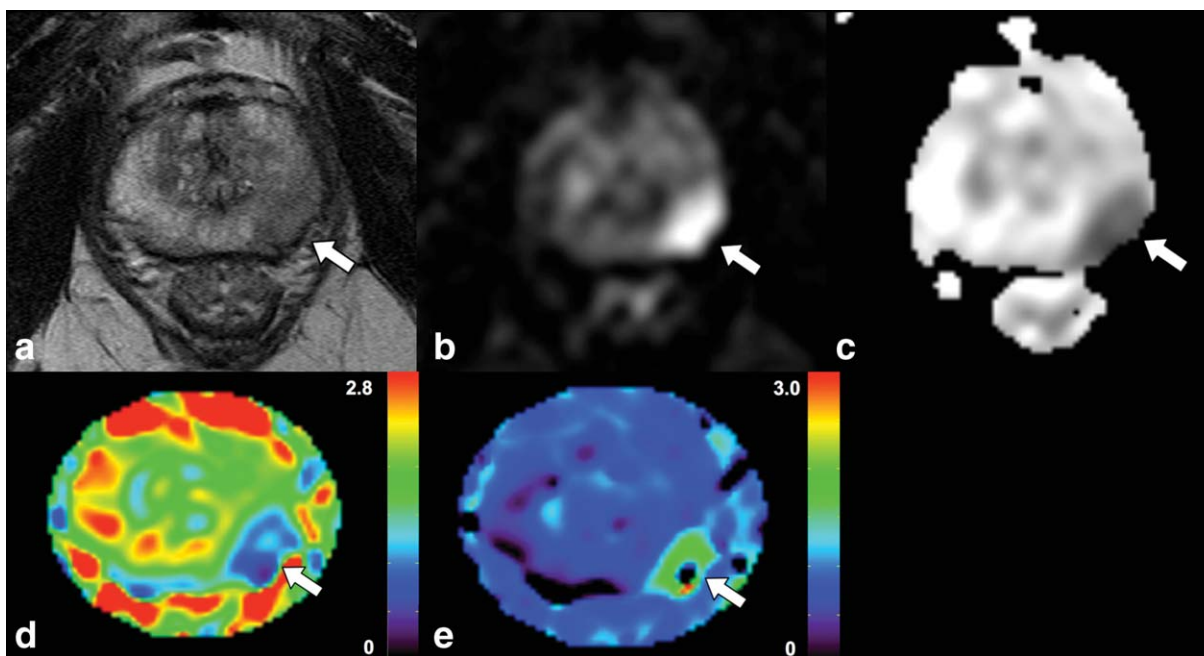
A 73-year-old man (prostate-specific antigen level, 12.1 ng/mL) with prostate cancer (arrows). T2-weighted image (T2WI) (a), diffusion-weighted image (DWI) ($b = 1500 \text{ s/mm}^2$) (b), apparent diffusion coefficient (ADC) map (c), D map (d), and K map (e). Compared with healthy tissue, prostate cancer in left peripheral zone showed hypointensity on T2WI, hyperintensity on DWI, hypointensity on ADC, lower D value, and higher K value.
